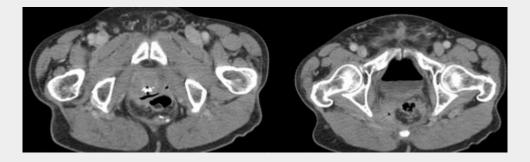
Abdominal CT of a 60 year old patient with fever a month after restorative proctocolectomy with ileal pouch-anal anastomosis
